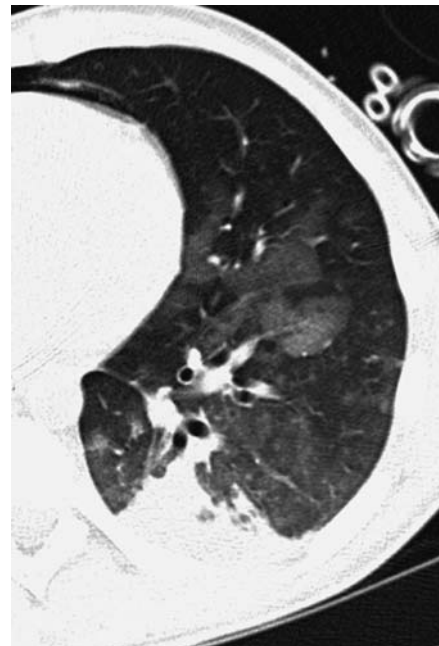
Transverse CT scan of the left lung in a lung transplant recipient. The combination of ground glass opacities and gravity-dependent consolidations are highly suggestive of acute rejection and resemble features seen in early ARDS
